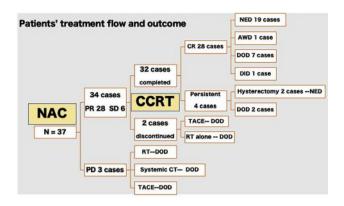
Treatment flow and outcome in the 37 enrolled patients. PR: Partial response; SD: stable disease; CCRT: concurrent chemoradiotherapy; RT: radiotherapy; CT: chemotherapy; DOD: dead of disease; CR: complete response, TACE: transcatheter arterial chemoembolization; NED: no evidence of disease; AWD: alive with disease; DID: dead of intercurrent disease.
